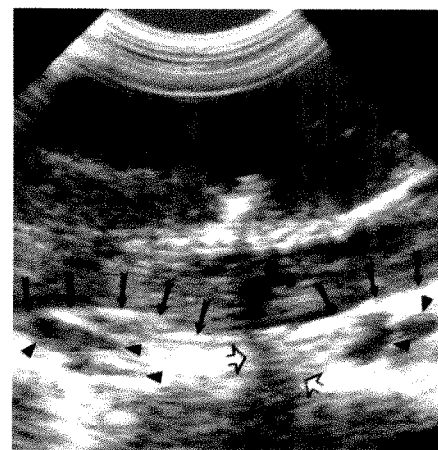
Epidural veins (canal stenosis). On longitudinal sonogram, epidural soft tissues, bounded dorsally by ventral dura (solid arrows), are prominent; within them are hypoechoic areas representing veins (arrowheads). Epidural soft tissues taper toward interspace (open arrows). When prominent veins such as these are present, small particles representing flowing blood may be seen during real-time sonography.
